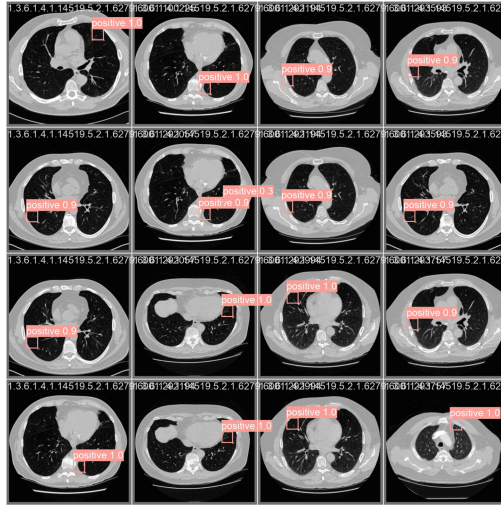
Experiment to identify tumors on lung CT images
